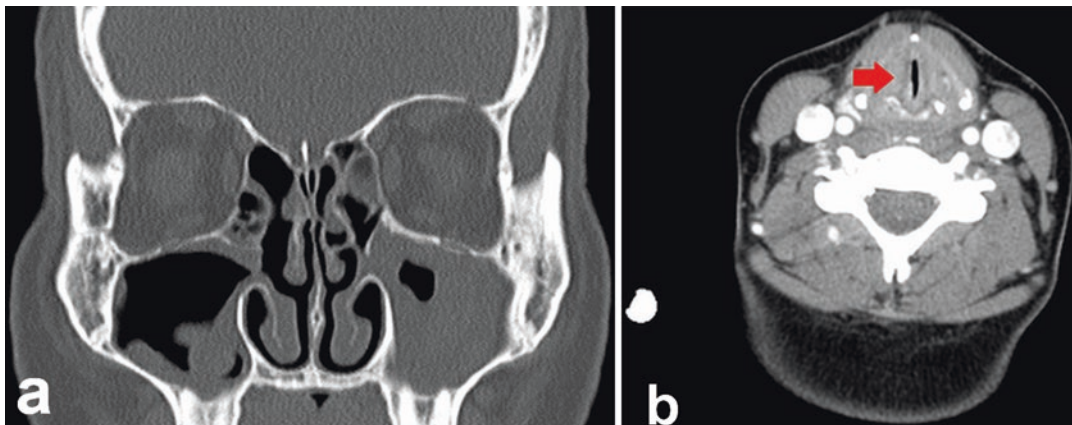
CT scan coronal plane of sarcoidosis patient. (a) Sinus disease and retention cyst. (b) Upper airway narrowing (arrow)
